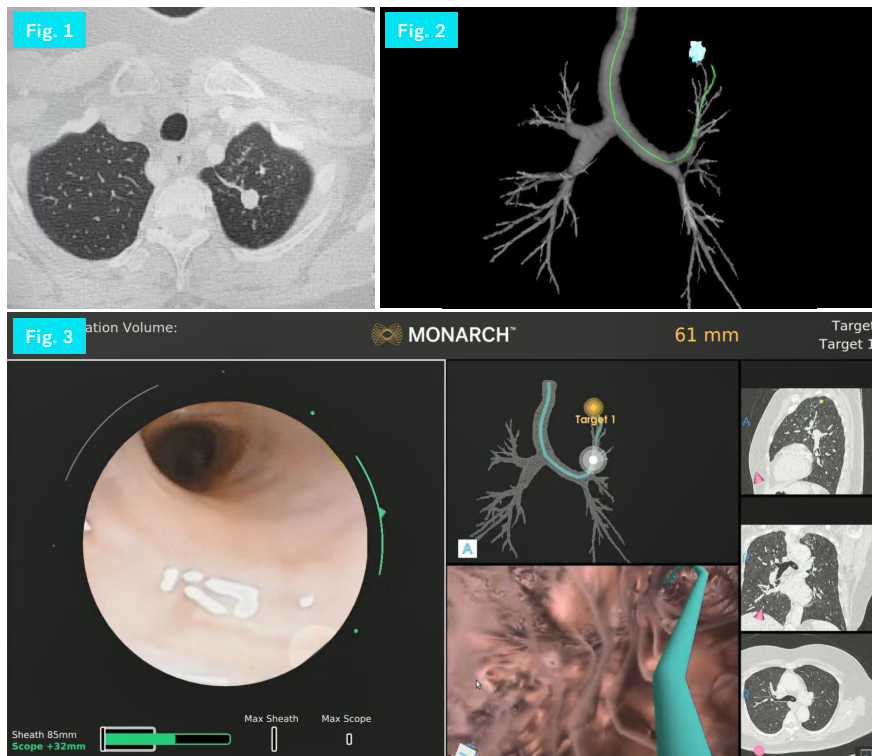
Axial CT of apical nodule
